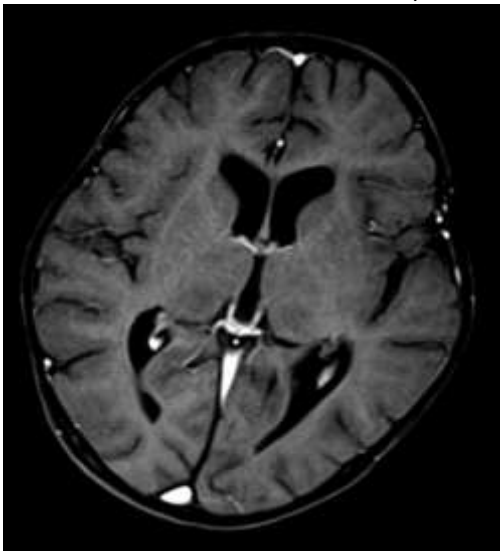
HSV encephalitis : 3yrs old female patient presents with sudden onset of high grade fever, altered sensorium, and recurrent seizures. Diffuse edema noted on CT image. T2 and FLAIR hyperintensity noted involving right frontal, parietal, temporal cortex and subcortical white matter, right parahippocampal gyrus, insular cortex, bilateral thalami, right half of pons, right cerebral peduncle, left coronaradiata, showing restriction on DW images, suggestive of cytotoxic edema. HSV encephalitis.
